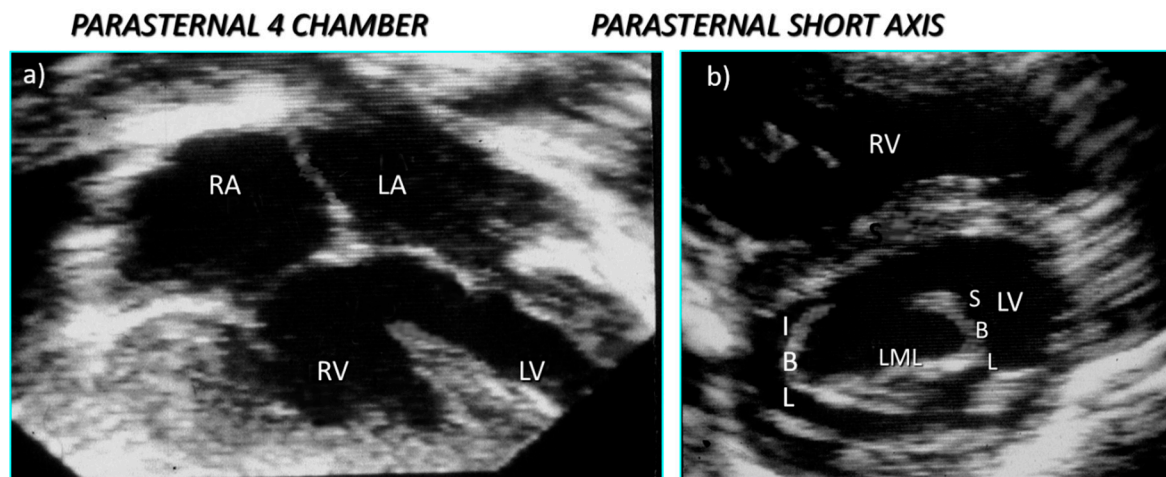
Echocardiographic sections from a heart with the form of AVSD in which (a) the parasternal four chamber section reveals the isolated interventricular communication and (b) the parasternal short axis section reveals the trileaflet left atrioventricular valve.
